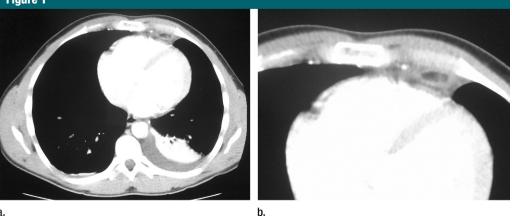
(a) Axial contrast-enhanced chest CT image shows encapsulated low-attenuation lesion with high-attenuation strands in the left paracardiac area. Mostly left-sided pleural effusion is present. There is no pericardial effusion. (b) Localized axial contrast-enhanced CT image in the left epipericardial area shows the oval-shaped fat attenuation lesion.
